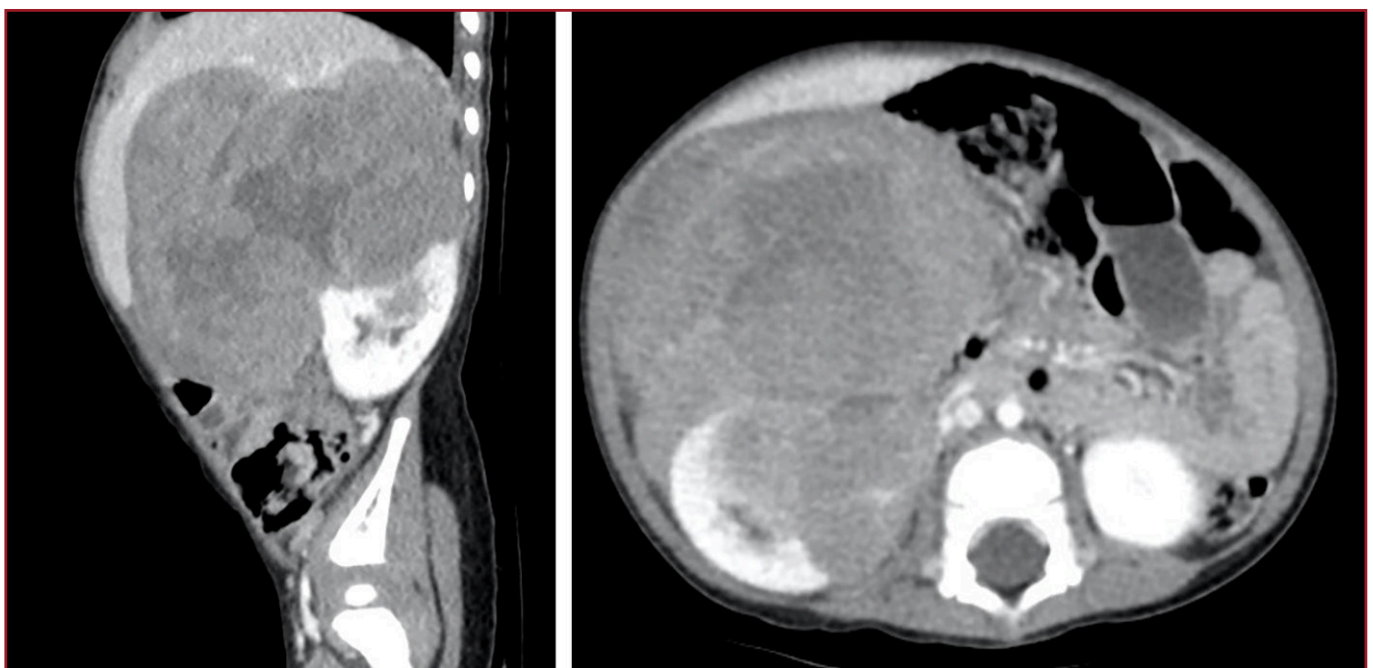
A computed tomography scan of the abdomen at presentation. A) A heterogeneous tumor at retroperitoneal space encases the adrenal gland and partial kidney, B) A heterogeneous tumor displaces the inferior vena cava.
